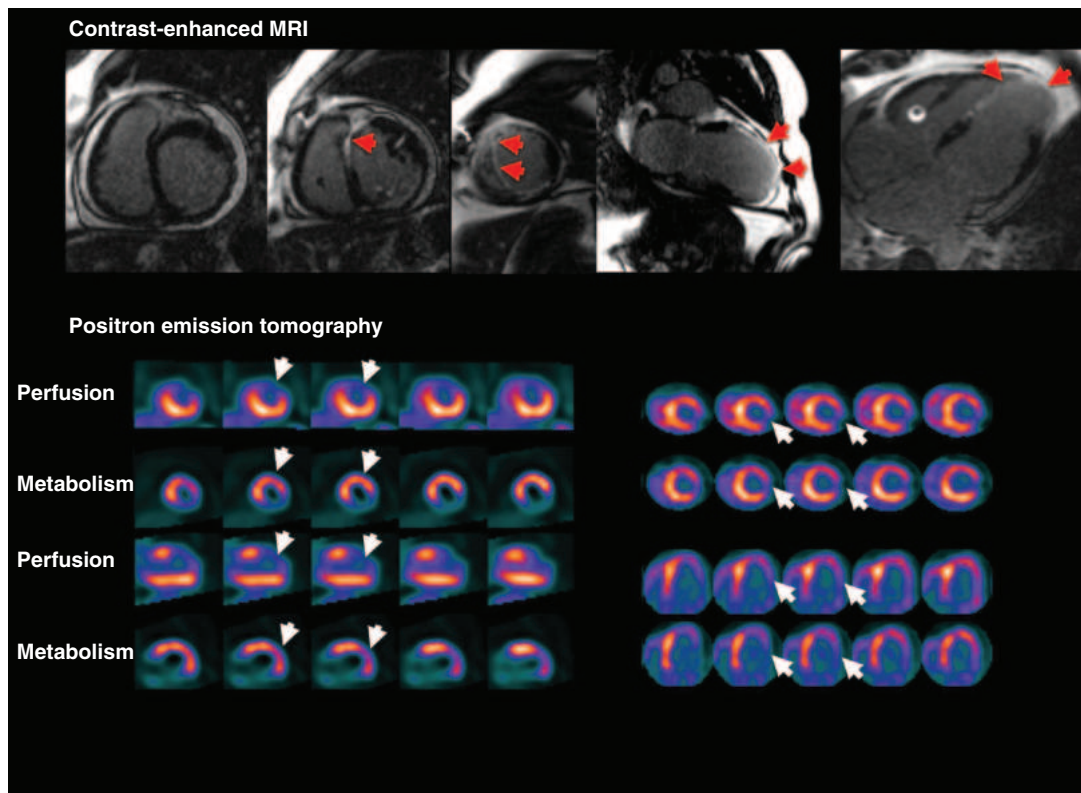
Examples of myocardial viability patterns obtained with cardiac magnetic resonance imaging (MRI) and positron emission tomography (PET) in three different patients with coronary artery disease. The *top panel* demonstrates extensive late gadolinium enhancement (*bright white areas*) involving the anterior, anteroseptal, and apical left ventricular walls (*arrows*), consistent with myocardial scar and nonviable myocardium. The *lower left panel* demonstrates rubidium-82 myocardial perfusion and ^{18}F -fluorodeoxyglucose (FDG) images showing a large and severe perfusion defect in the anterior, anterolateral, and apical walls, indicating preserved glucose metabolism (so-called *perfusion-metabolic mismatch*) consistent with viable myocardium. The *right lower panel* shows similar PET images demonstrating concordant reduction in perfusion and metabolism (so-called *perfusion-metabolic match*) in the lateral wall, consistent with nonviable myocardium.
